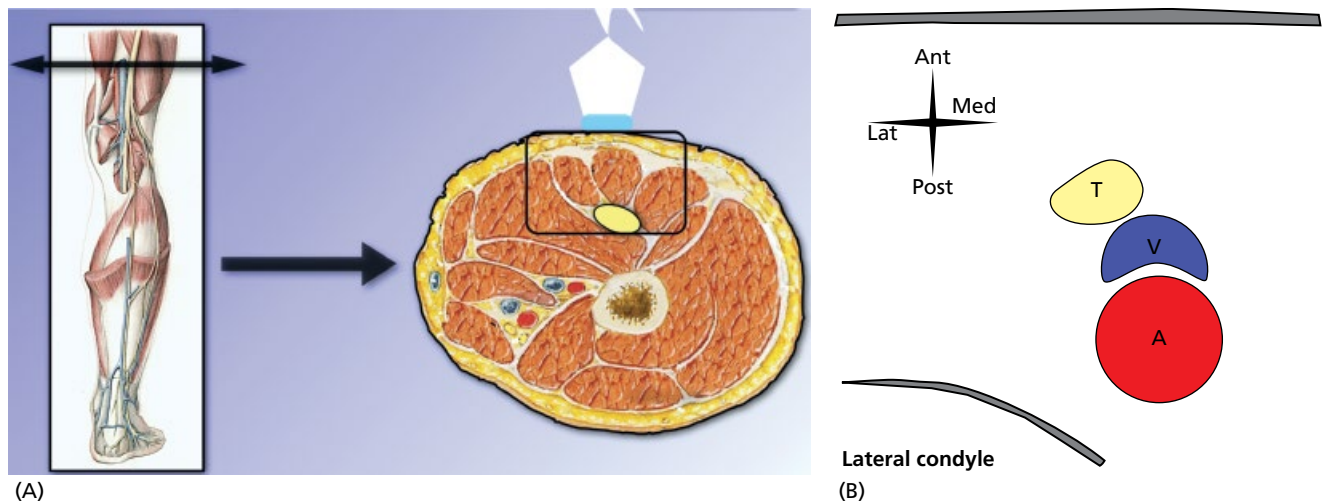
The popliteal sciatic region. (A) Anatomy. (B) Ultrasound image. At the popliteal crease, a transversely positioned linear probe captures the tibial and common peroneal nerves, the former located medially and lateral to the adjacent popliteal vessels. The tibial nerve is often located in close proximity to the tibial artery and the tibial vein. The nerves appear round-to-oval and hyperechoic compared with the surrounding musculature. The hyperechoic border of the femur (condyles) may be apparent. (C) Ultrasound image at the popliteal crease. (D) Ultrasound image where the sciatic nerve bifurcates. T, tibial nerve; A, tibial artery, V, tibial vein. See text for further details.
